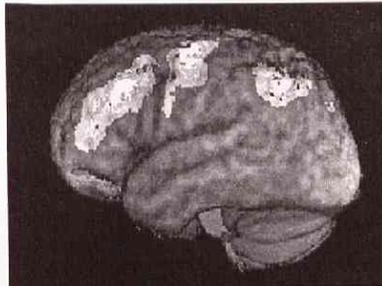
An MRI image of a human brain showing areas of activation relating to short-term memory and attention
